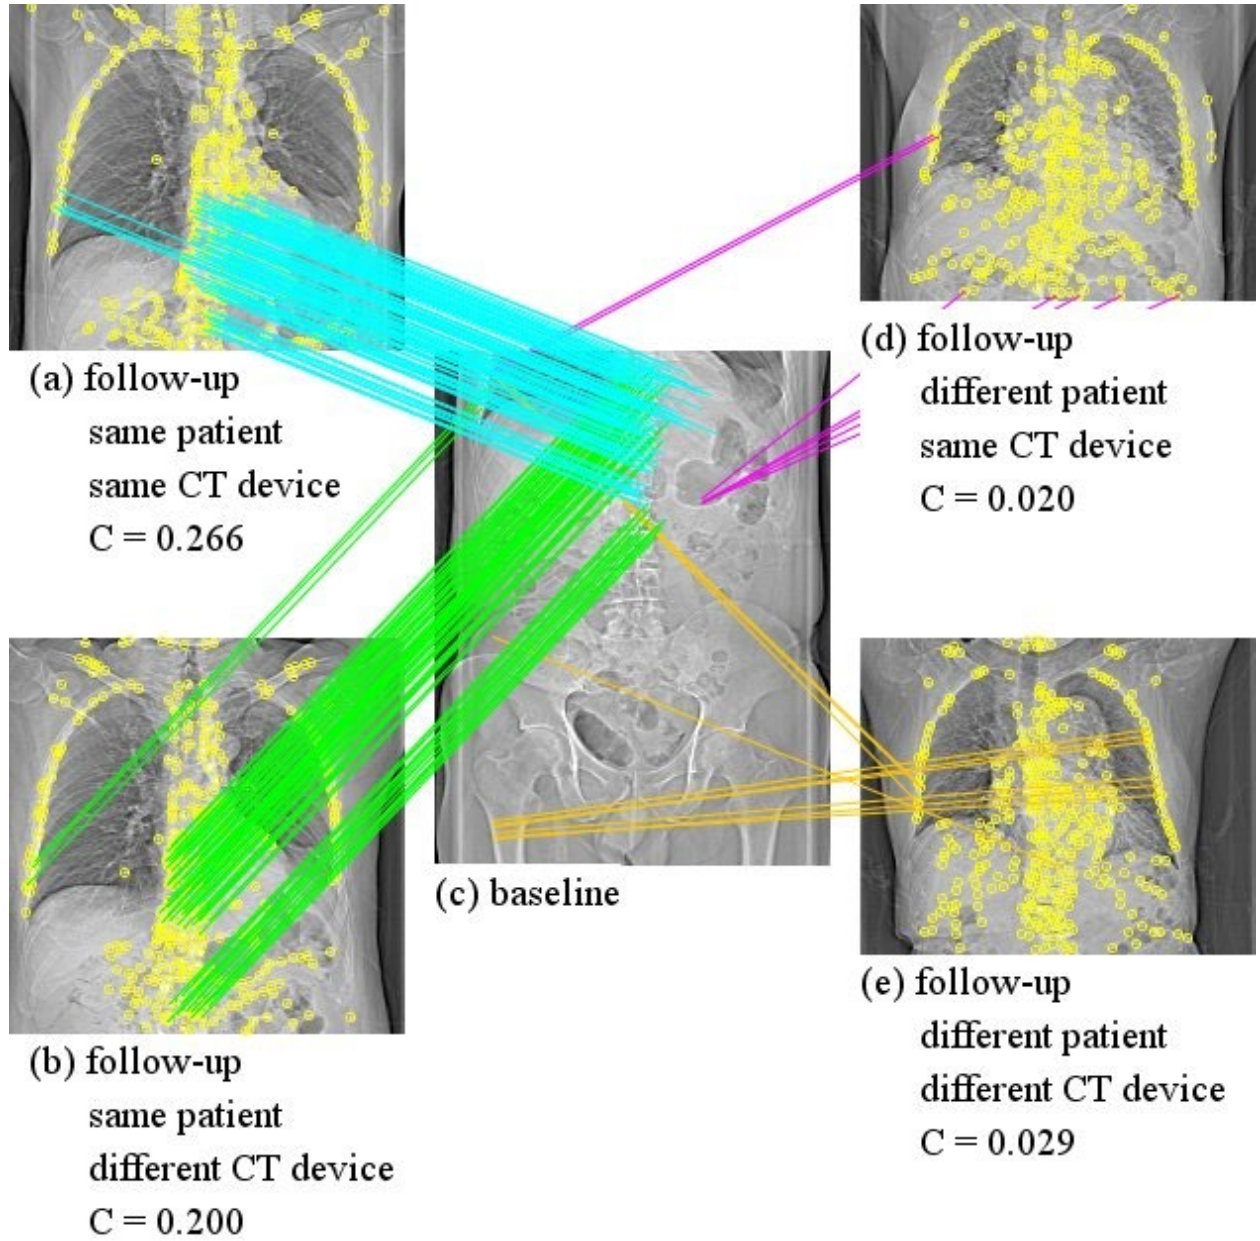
Example images of the same and different patient-pair analyses with two computed tomography (CT) devices using the proposed method ($D = 2.0$, $K = 2000$, $X = Y = 12$, $N = 350$). The scan condition of each scout image is as follows: the center (c) is of the baseline examination acquired using a SOMATOM Sensation64 device, the top-left (a) is of a follow-up examination of the same patient (c) acquired using the same device, the bottom-left (b) is of a follow-up examination of the same patient (c) acquired using a different device (SOMATOM Definition), the top-right (d) is a follow-up examination of a different patient (C) acquired using the same device, and the bottom-right (e) is a follow-up examination of a different patient (c) acquired using
